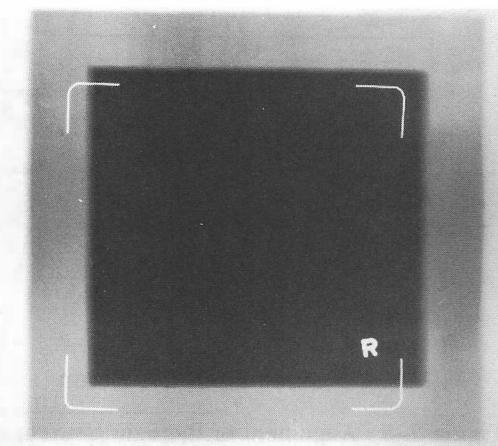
Test film of light and x-ray beam alignment
